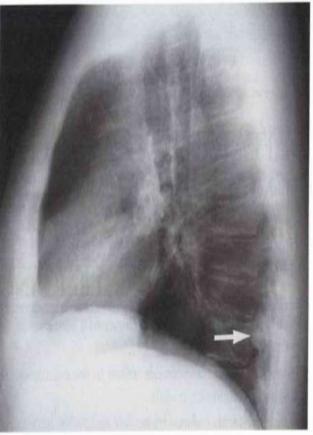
Granuloma. A: PA chest radiograph shows a small, well-circumscribed, round opacity at the right lung base (arrows). B: Lateral view shows that the opacity is within the lung on two views (posterior segment of the right lower lobe) and thus represents a pulmonary nodule (arrow). The high density of the nodule relative to its small size indicates that it is densely calcified. The appearance is characteristic of a benign calcified granuloma, and no further evaluation of the nodule is needed (an exception would be in a patient with a known calcium-producing primary tumor, such as osteosarcoma, which can lead to calcified pulmonary metastases; in this case, older radiographs confirmed over 2 years of stability of the granuloma).
